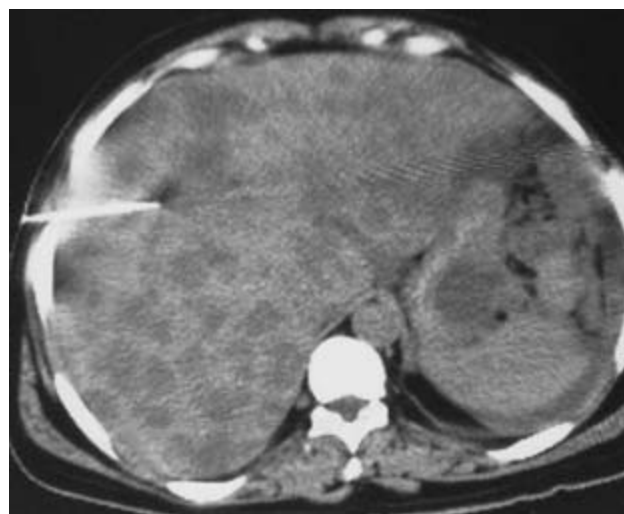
CT scan of widespread hepatic metastases from a primary in the colon. A biopsy needle is directed into one of them.
